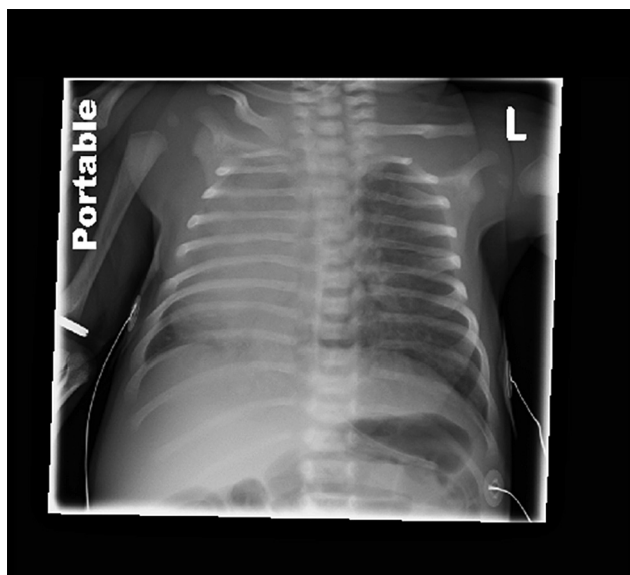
Chest radiography demonstrated the dextro-position of the cardiac silhouette occupies almost entire right chest.
